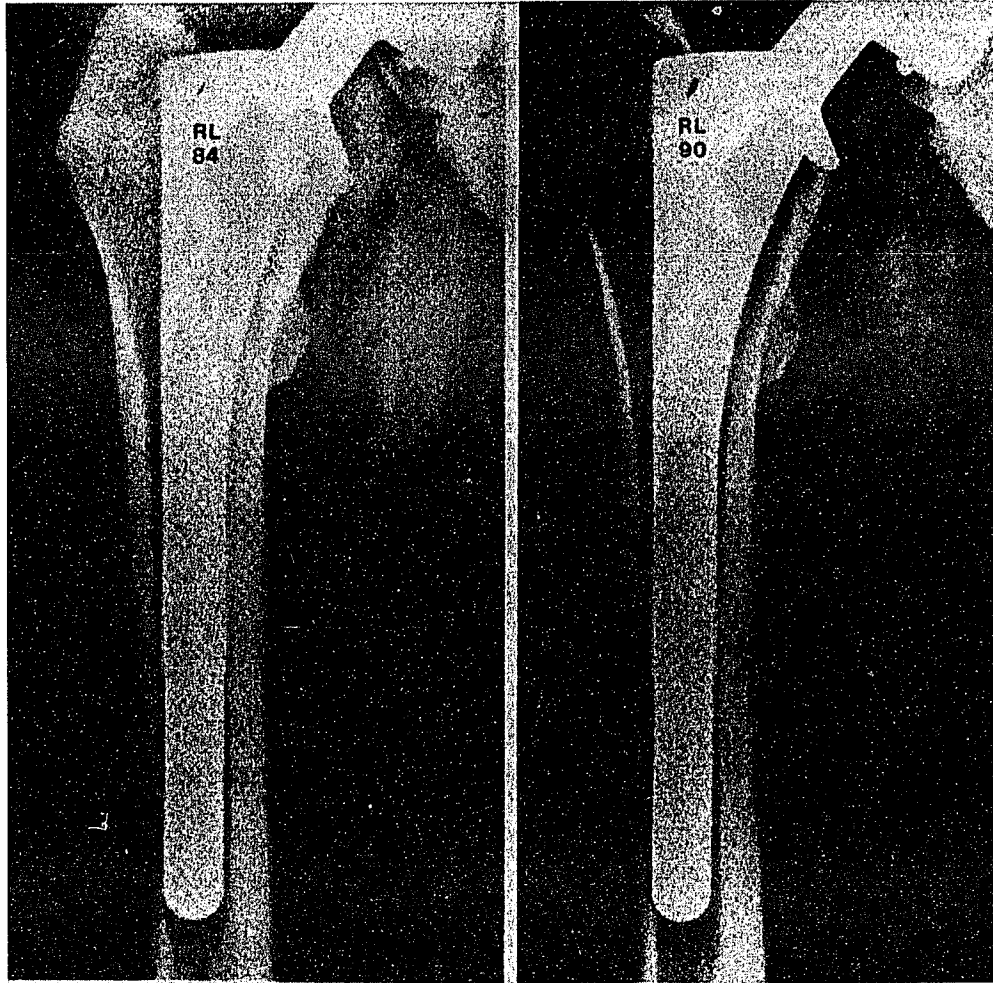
(a) Clinical radiograph made immediately after *in vivo* implantation of the prosthesis, when the patient was sixty-two years old, shows bone of excellent quality. (b) The final radiograph made before the patient's death demonstrates resorptive remodeling of the lateral and medial cortices. (from fig. 2-A and 2-B, Engh *et al.* 1992)
